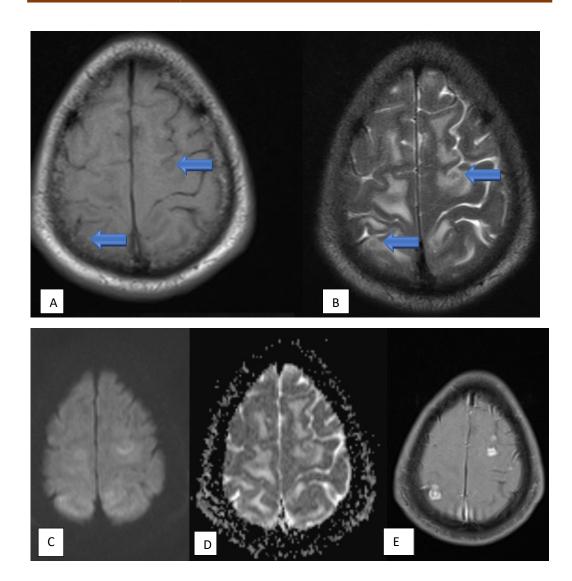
Tuberculoma- Caseating Granulomas without central liquefaction (A–E) MRI images (A) Axial T1WI (B) Axial T2 WI (C) Axial DWI (D) Axial ADC map (E) Axial T1W post contrast. These images show few, variable sized, T1 iso and T2 hypointense lesions with T2 hypointense rim (blue arrows) and moderate perilesional edema in bilateral high parietal lobes with no restricted diffusion on DWI. ADC value obtained was 1.1 x 10⁻³ cm/s On post contrast, the lesions show thick ring enhancement – *likely caseating granulomas without central liquefaction*.
